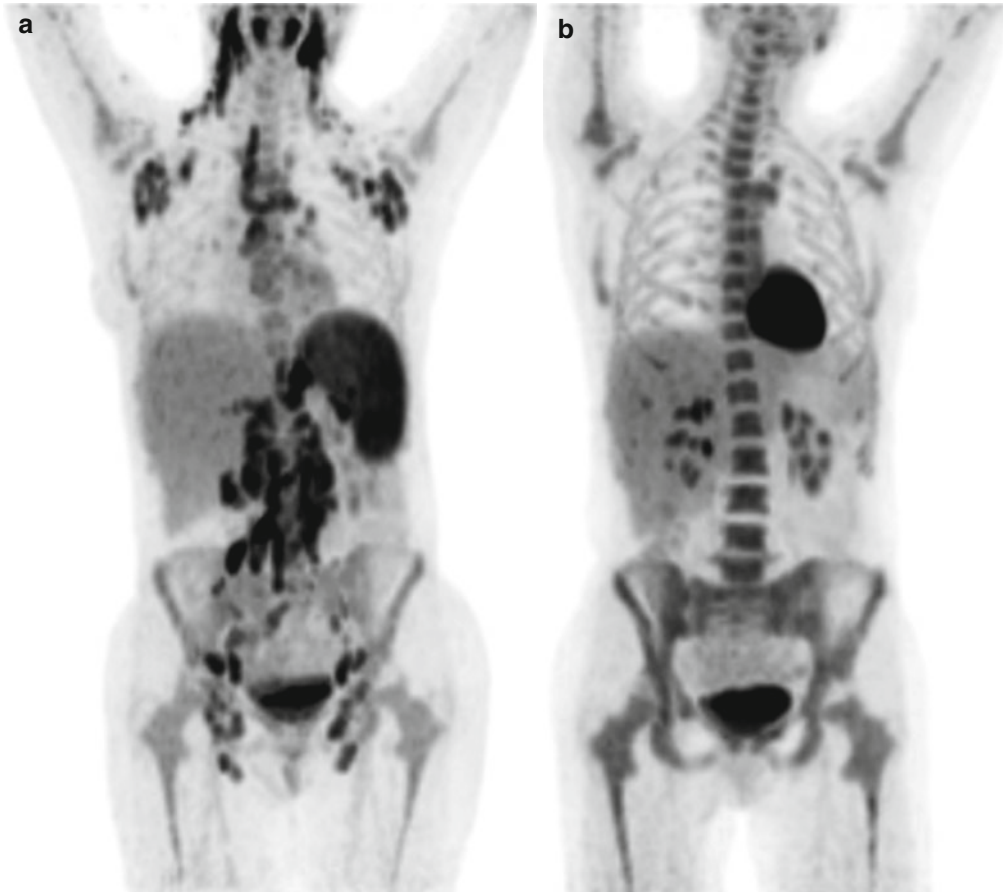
^{18}F -FDG-PET in Hodgkin's lymphoma before (a) and after (b) two cycles of chemotherapy. The maximum intensity projection images demonstrate a complete
